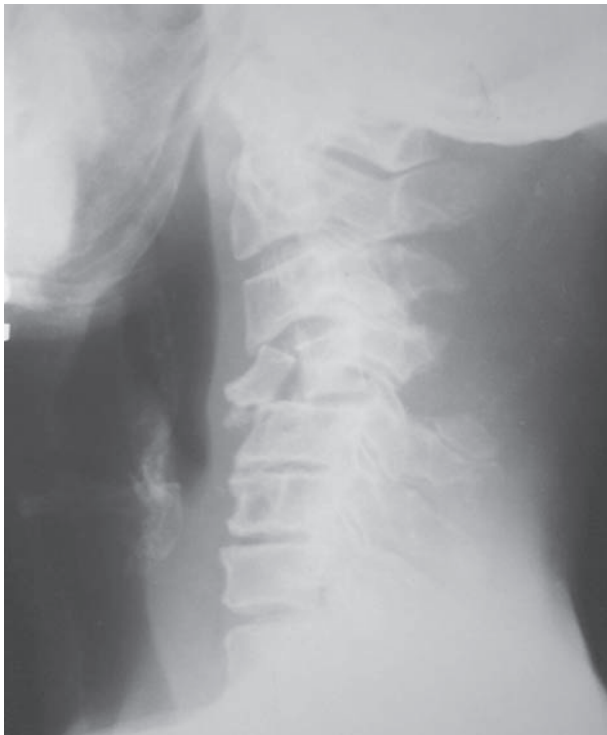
X-ray cervical spine showing C4 fracture
